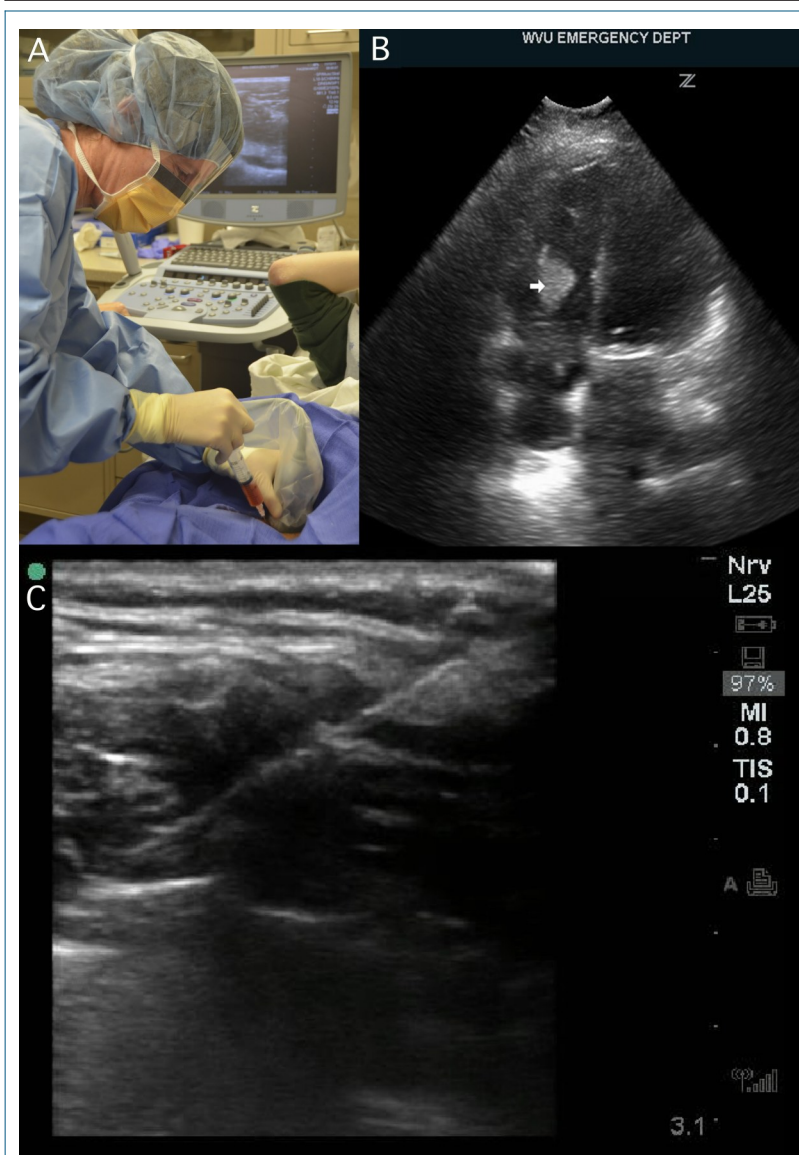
Expanding Ultrasound Training Gives Patients Broader Access to Specialized Care.
